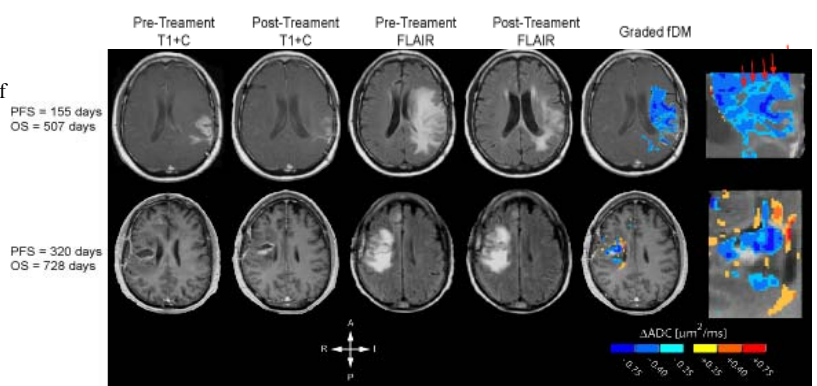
Pre- and post-treatment contrast-enhanced T1w and FLAIR images along with graded fDM for two patients. Regions of light blue represent regions of suspected tumor burden having 0.25 $\mu\text{m}^2/\text{ms} < \Delta$ ADC < 0.40 $\mu\text{m}^2/\text{ms}$.
